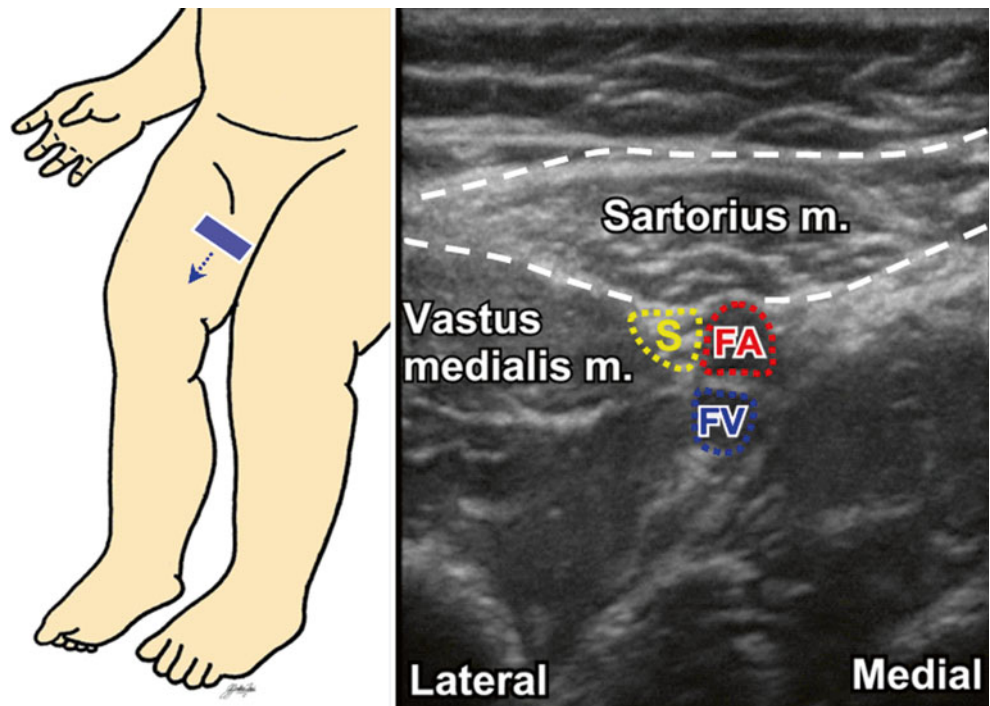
Ultrasound image showing the saphenous nerve in the adductor canal. Often, the probe is moved distally until the femoral artery is further away from the nerve. *S* saphenous nerve, *FA* femoral artery, *FV* femoral vein
